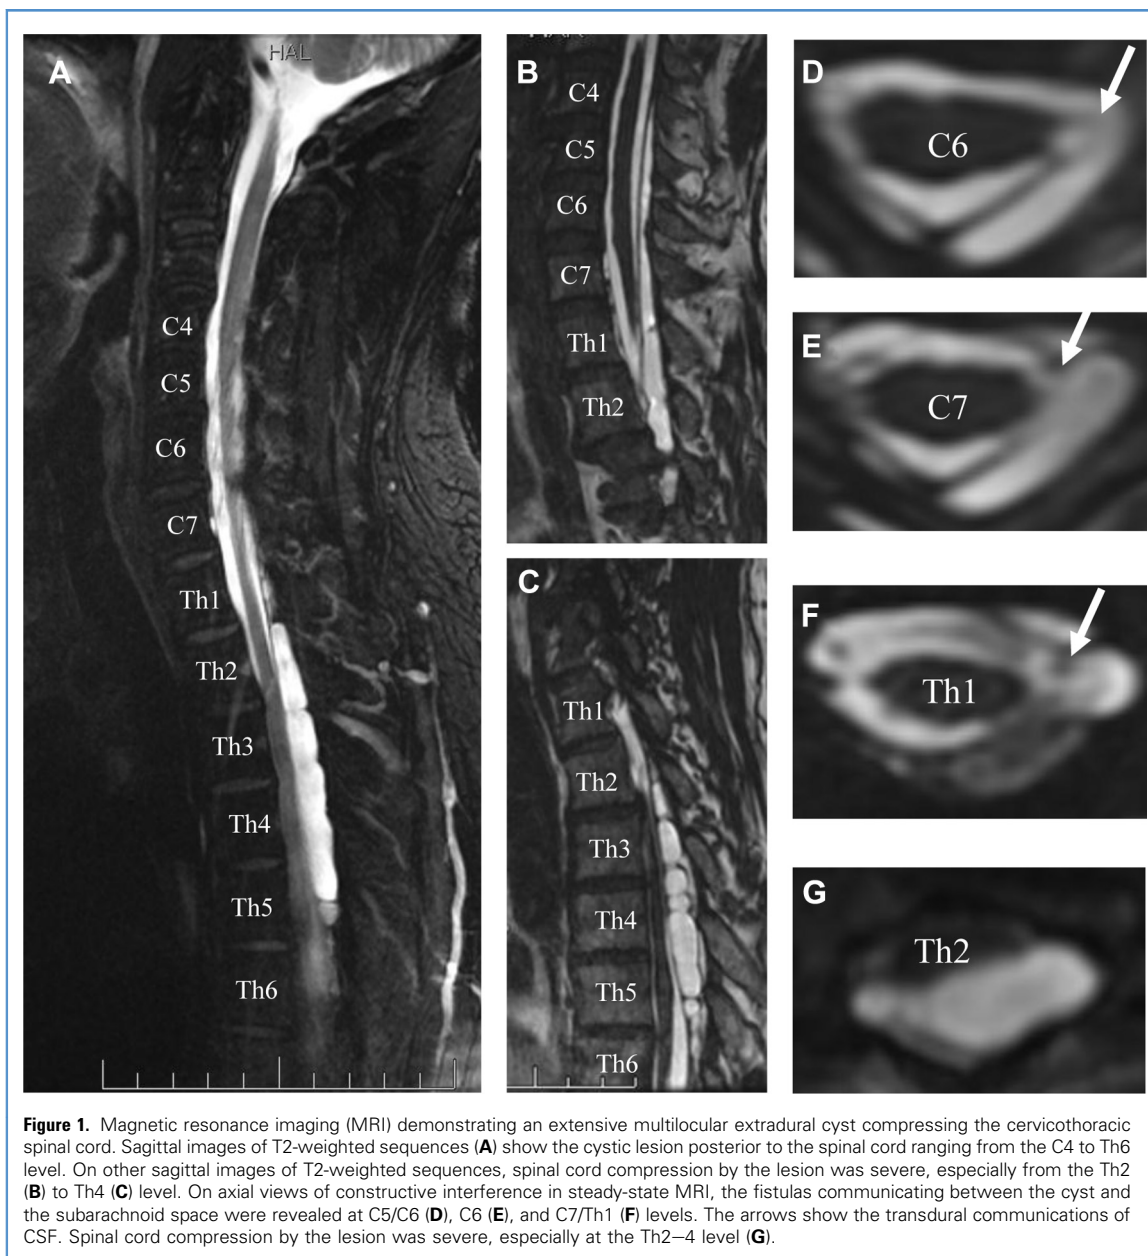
Magnetic resonance imaging (MRI) demonstrating an extensive multilocular extradural cyst compressing the cervicothoracic spinal cord. Sagittal images of T2-weighted sequences (A) show the cystic lesion posterior to the spinal cord ranging from the C4 to Th6 level. On other sagittal images of T2-weighted sequences, spinal cord compression by the lesion was severe, especially from the Th2 (B) to Th4 (C) level. On axial views of constructive interference in steady-state MRI, the fistulas communicating between the cyst and the subarachnoid space were revealed at C5/C6 (D), C6 (E), and C7/Th1 (F) levels. The arrows show the transdural communications of CSF. Spinal cord compression by the lesion was severe, especially at the Th2–4 level (G).
